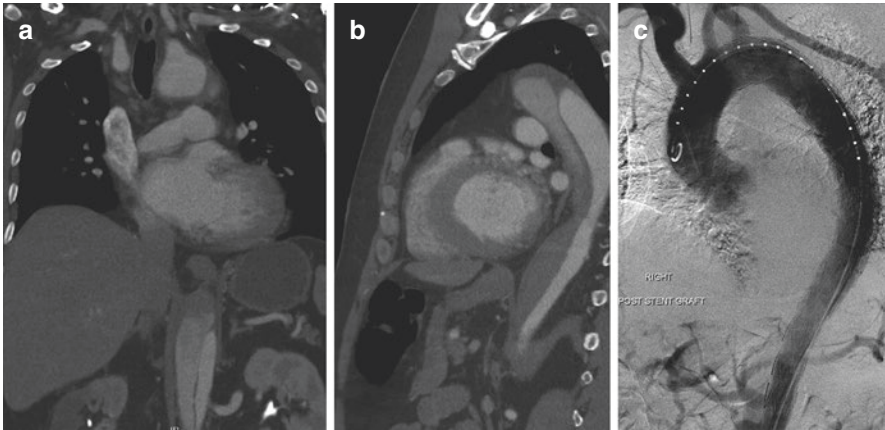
(a and b): Coronal and sagittal views of CT angiography of a 56-year-old male who presented to our institution with an acute symptomatic DeBakey IIIb dissection complicated by right kidney malperfusion and acute renal failure. (c): completion angiography following an emergent thoracic endovascular aortic repair. This patient underwent placement of a lumbar drain prior to the procedure, which had to be clamped due to bloody CSF. He developed paraplegia on post-operative day 1, prompting lumbar drain replacement. He was initiated on 7 days of SCI treatment protocol and regained all neurologic function of the bilateral lower extremities. He was subsequently discharged home
